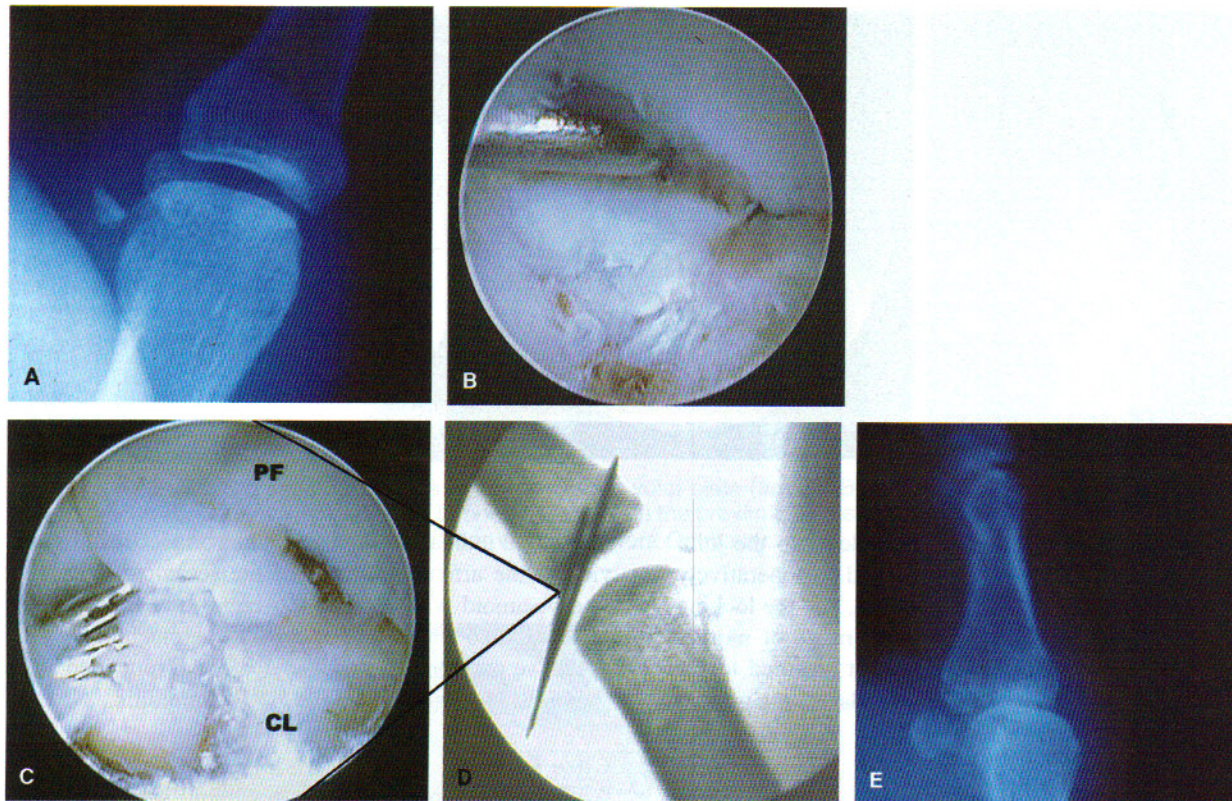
A. AP x-ray of the thumb, showing a displaced articular fracture of the proximal phalanx at the insertion of the ulnar collateral ligament. This represents a ligamentous avulsion. B. Arthroscopically assisted pinning of the intra-articular fragment of the proximal phalanx (PF) after reduction with a nerve hook. Note the fraying of the collateral ligament (CL) under the osteochondral fragment. C. The osteochondral fragment with the K-wires in place. The wires are placed manually through the skin, compressing the fragment in. Once reduction is achieved, the wires are drilled through the phalanx. D. Postoperative x-ray of the fracture reduced and pinned with crossed K-wires. E. At 2 months, the fracture is healed anatomically, and stability of the thumb has been restored.
